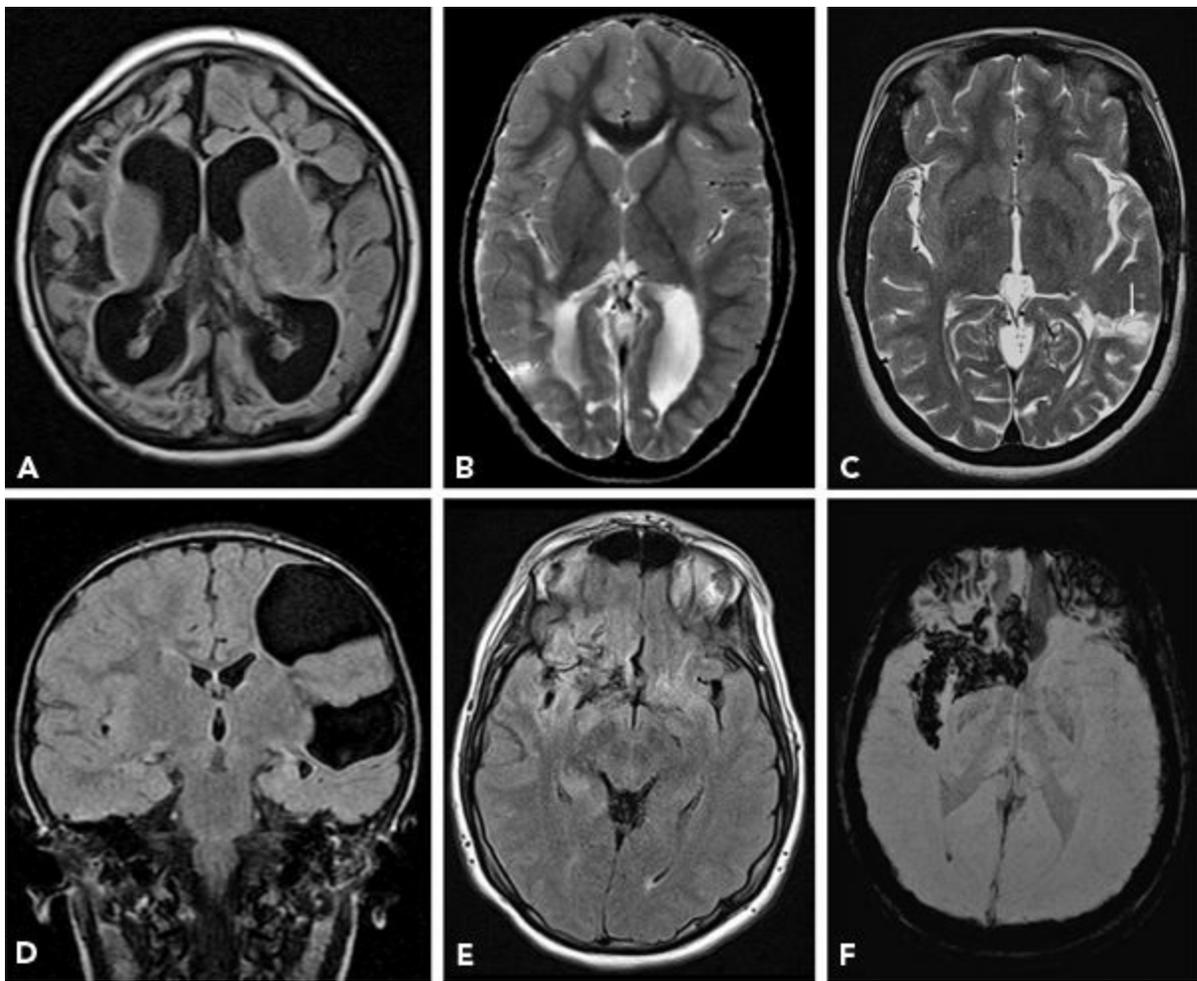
Porencephaly and encephalomalacia of various etiologies. A: Diffuse multicystic encephalomalacia and gliosis secondary to global hypoxic ischemic injury. B: Periventricular leukomalacia due to perinatal brain injury. C: Left posterior temporal encephalomalacia due to prior ischemic stroke in a patient with sickle cell anemia. D: Porencephalic cysts in left frontal and temporal lobes related to multiple hemorrhages in the neonatal period. Also, note left MTS. E, F: Encephalomalacia due to remote herpes encephalitis on FLAIR images (E). Susceptibility-weighted images (F) show marked hypointensity in the regions of prior petechial hemorrhages.
